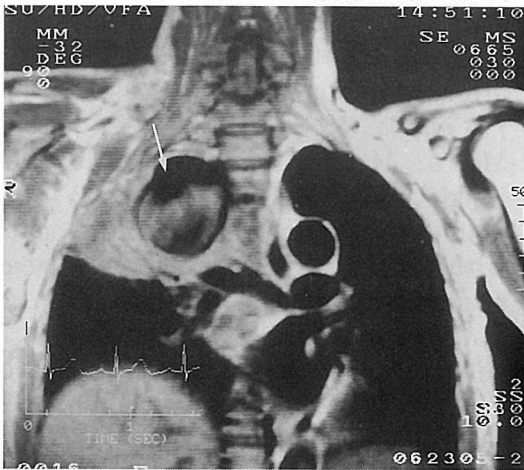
E, T1-weighted MR imaging shows its flow-void appearance (arrow).
